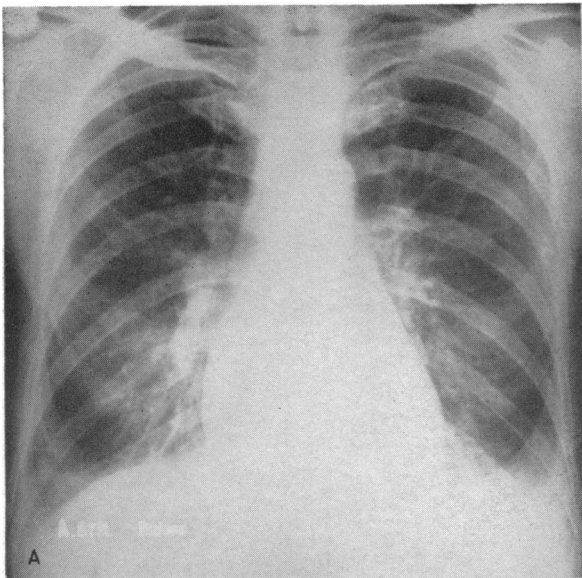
Six-foot postero-anterior radiographs of Case 5. A. Before treatment, showing bilateral pleural effusions, prominent pulmonary arteries, and slight cardiomegaly. B. After treatment, showing reduction in heart size and disappearance of pleural effusions.
